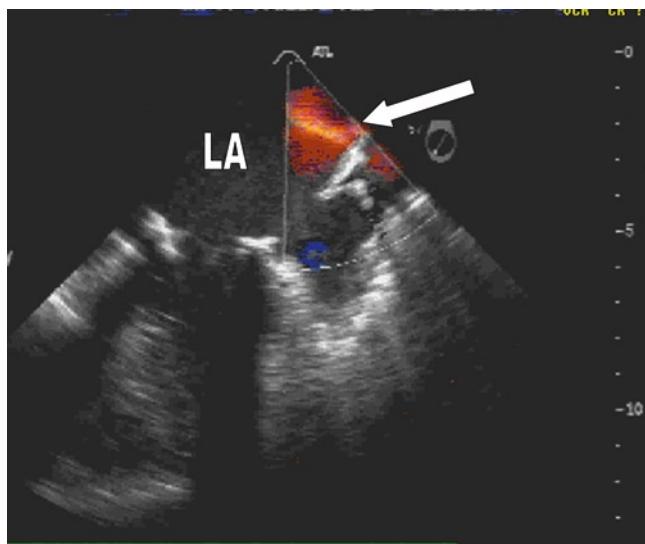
Transesophageal echocardiography image of a stenotic left pulmonary vein anastomosis, highlighted by the turbulent color flow Doppler signal (arrow). LA left atrium.
